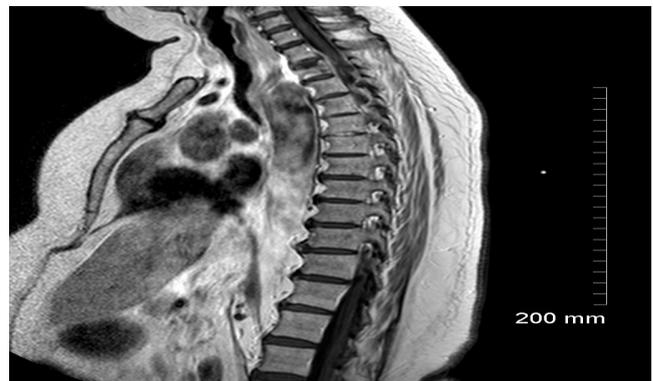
MRI spine demonstrating lytic lesion of T2 vertebral body
